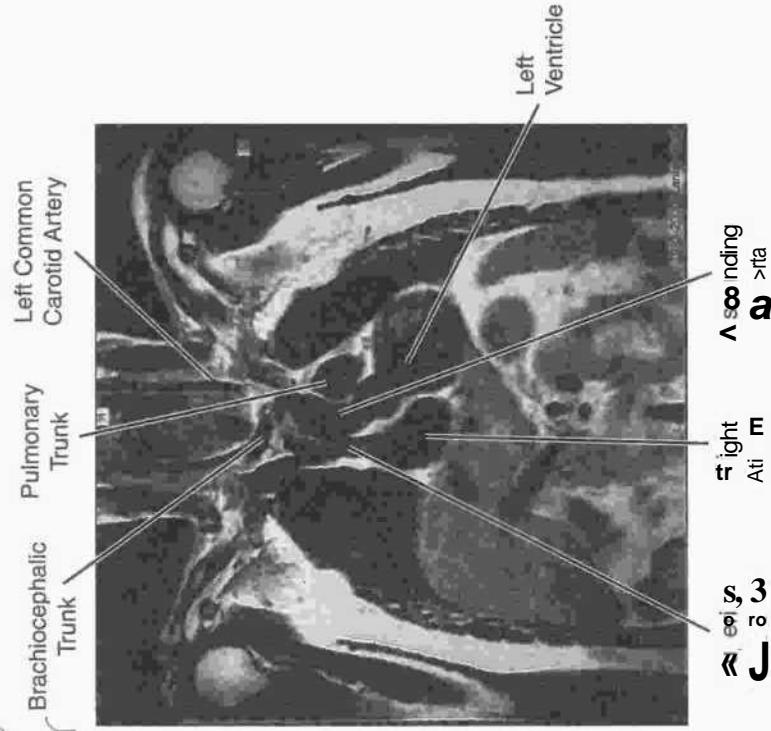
Chest: MRI, Axial T₆
